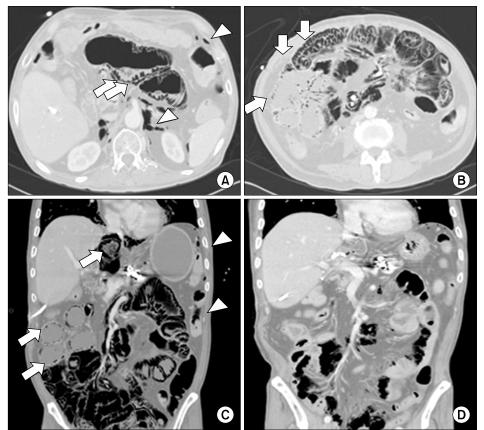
Imaging of the case 3: Computed tomography (CT) scan demonstrated pneumatosis intestinalis (white arrows) involving the entire bowel with pneumoperitoneum (white arrowheads) and pneumoretroperitoneum (white arrowheads) (A-C). After 1 week of treatment, gas was almost completely resolved (D).
